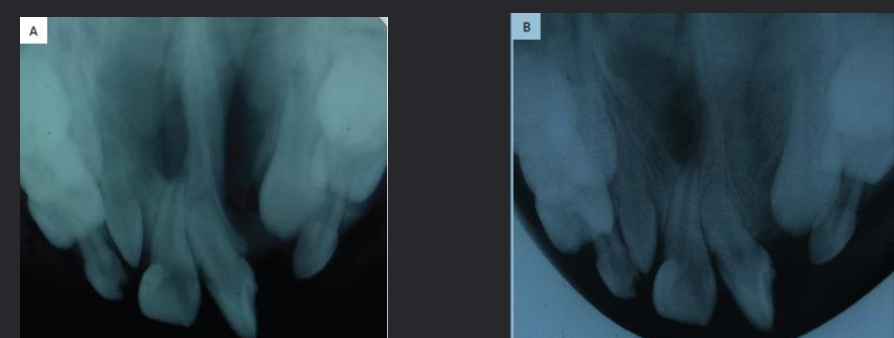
Occlusal radiographs of a left unilateral cleft lip and palate: (A) before alveolar bone graft and (B) after alveolar bone graft
